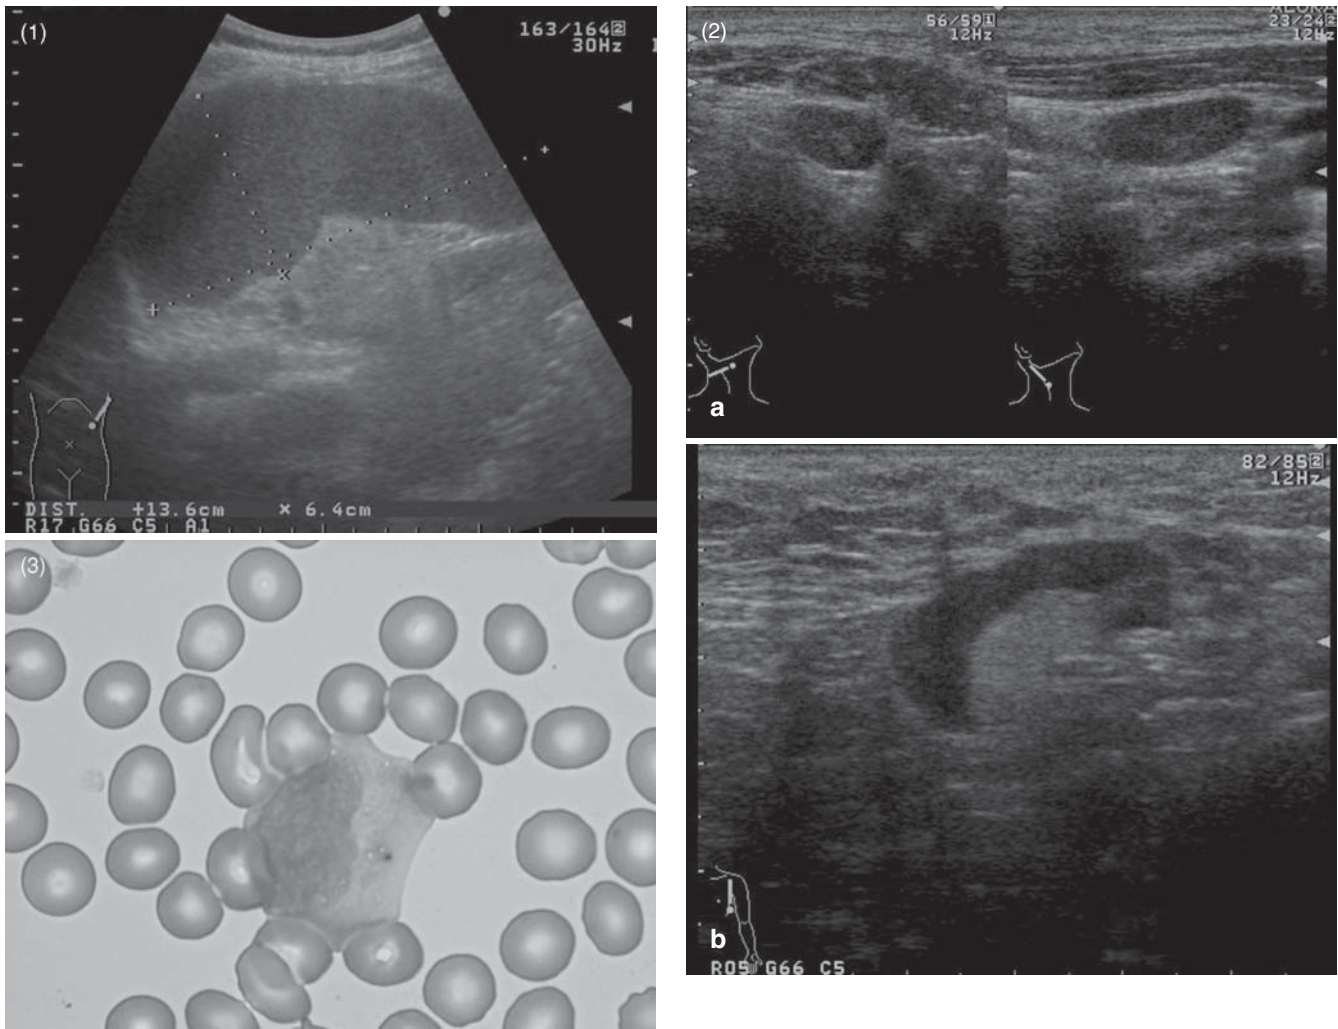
(1) Abdominal ultrasonography shows marked splenomegaly (131.6 × 6.4 cm). (2) Ultrasonography shows cervical (a) and axillary (b) lymphadenopathy. (3) Atypical lymphocytes in a peripheral blood smear (×1000)
